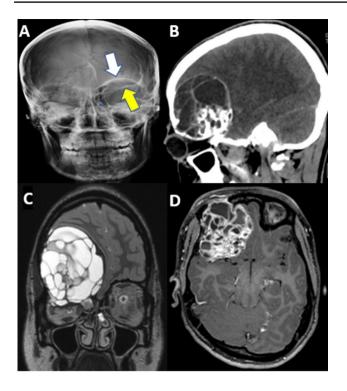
Preoperative imaging. A X-ray skull AP view—sclerosed sphenoid ridge and superior orbital wall. A normal sphenoid ridge and an orbital wall on the left side are shown by yellow and white arrows, respectively. B CT lateral view—calcified lesion. C T2 MRI—multiseptated cystic lesion. D Contrast MRI—enhancement of septa
